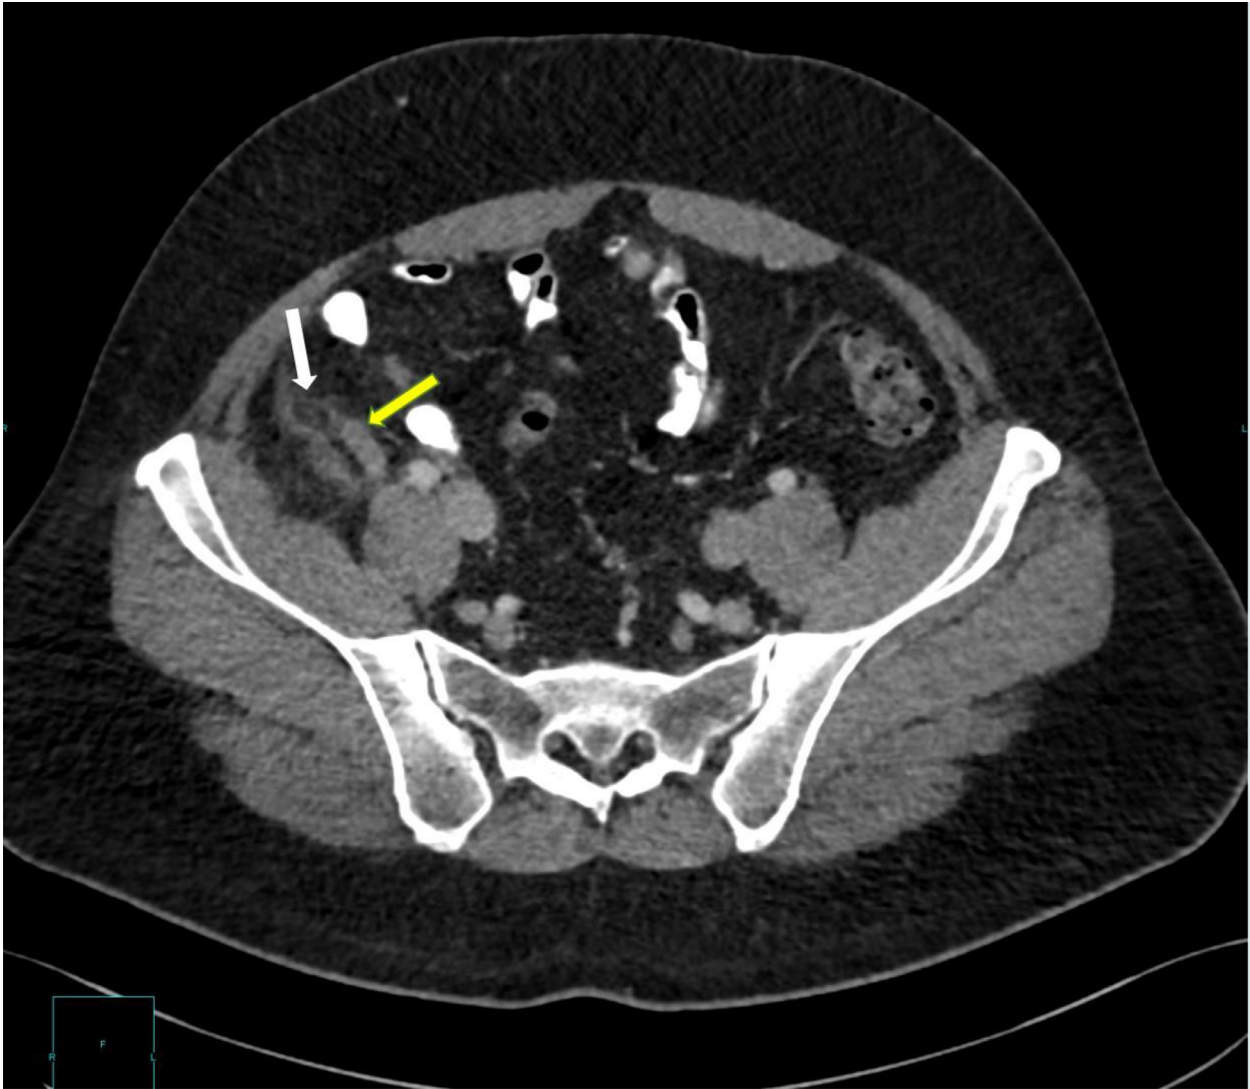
Axial CT image of the abdomen in the venous phase demonstrates normal appendix (yellow arrow). A small fat containing ovoid structure (white arrow) with peripheral hyperdense rim and surrounding fat stranding is seen adjacent to the appendix, suggestive of epiploic appendagitis of the appendix.
